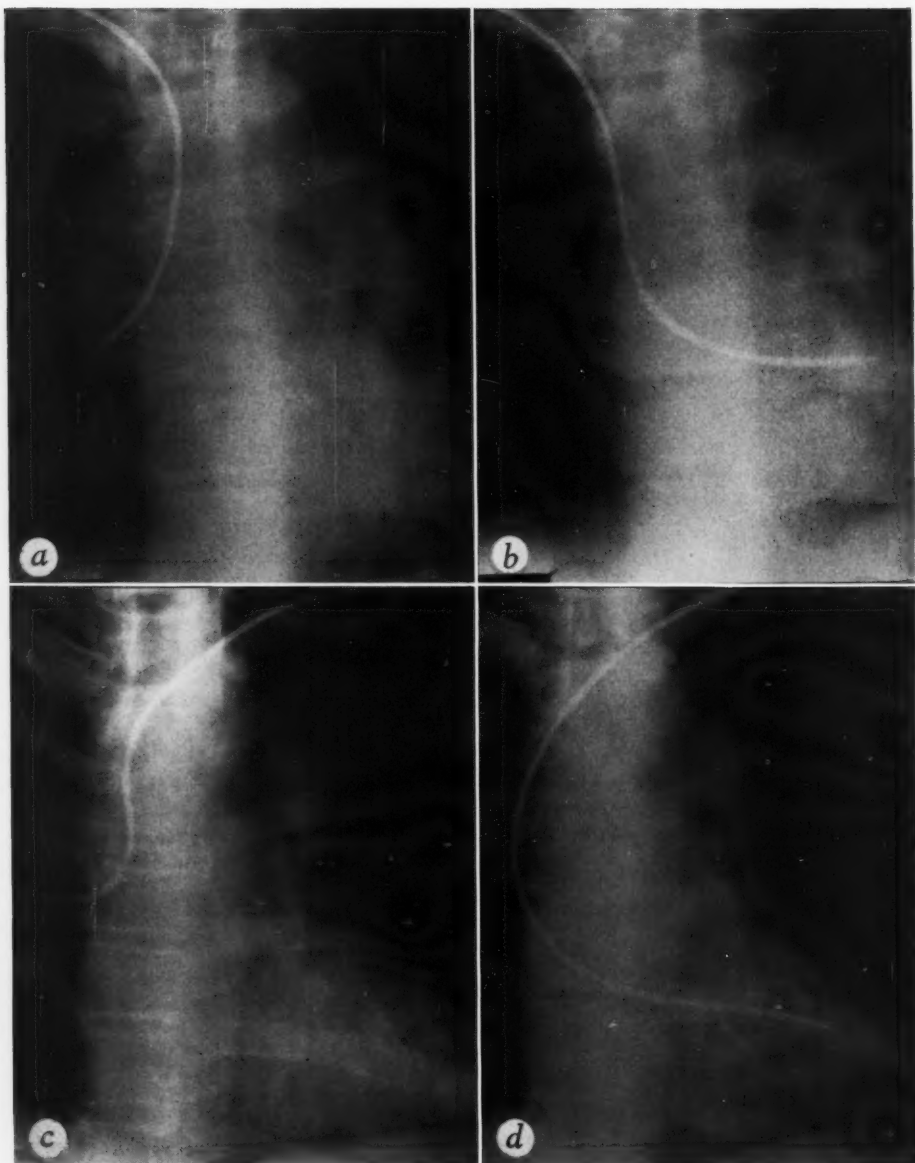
Roentgenograms obtained at cardiac catheterization: *a* and *b*, from case 3; *c* and *d*, from case 6. The tip of the catheter was in the right superior pulmonary vein (*a* and *c*) and in the left ventricle (*b* and *d*). Note (*a* and *c*) that the catheter entered the pulmonary vein above the main bulge of the right atrial chamber. This high location of the shaft of the catheter makes it extremely unlikely that it traversed an atrial septal defect of the usual type before entering the pulmonary vein.
